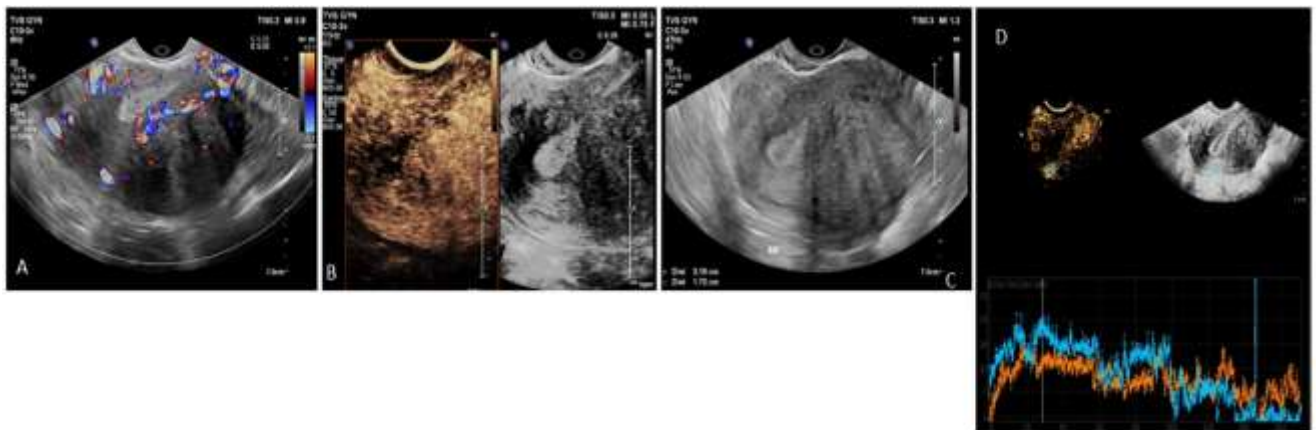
B mode (C) and color doppler (A) images of the posterior uterine lesion showing mild heterogenous enhancement with posterior shadowing (C). TIC curves (D) blue ROI in the lesion and red ROI in the normal surrounding parenchyma.
